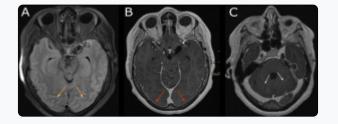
Bilateral occipital cortical oedema in FLAIR hyperintensity (orange arrows, A) in a patient with cortical blindess at wake-up after aneurysm embolisation. Dural (B, red arrows) and leptomeningeal (C, white arrows) enhancement on T1 after gadolinium.
